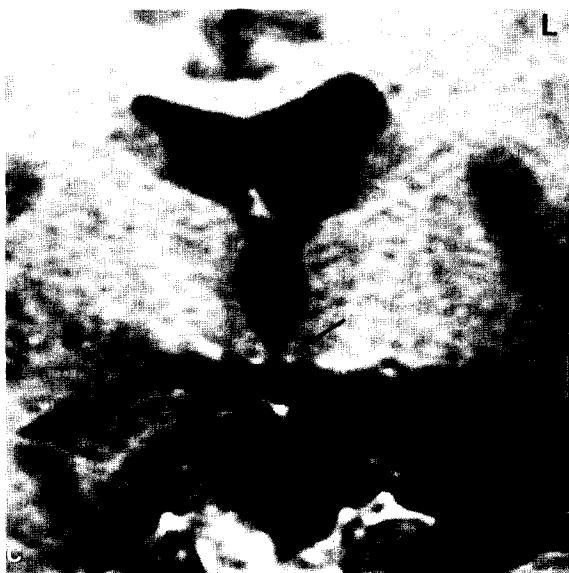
Coronal SPGR MR images, 4 months after the onset of amnesia, through the head (a) and posterior body (b) of the right hippocampus, at comparable levels to Fig. 3(a) and (b), demonstrate atrophy of the entire right hippocampus. The hippocampal volume measures  $1932 \text{ mm}^3$ , a reduction of 36%.
